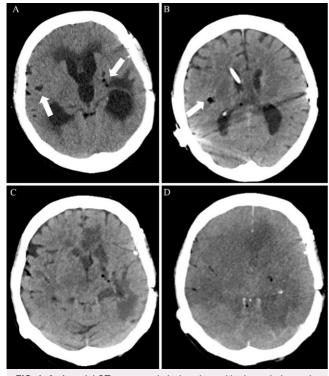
A: An axial CT scan on admission showed hydrocephalus and lipid-equivalent hypodense lesions (*white arrows*, -100 HU). B: Emergency axial CT scan obtained 7 days after admission displays decrease of hydrocephalus after insertion of a VP shunt and lipid-equivalent hypodense lesions (*white arrow*). Multiple infarctions are shown in the axial CT scan 10 days after admission (C). Global brain edema on the axial CT scan 17 days after admission (D).
